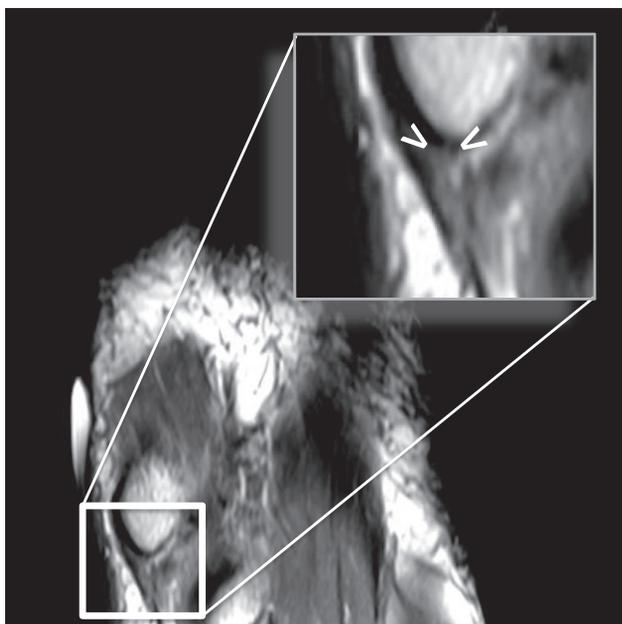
Axial T2-weighted and fat-saturated image of the right foot depicting the peroneal brevis at the insertion on the fifth metatarsal. Insert shows magnified view with abnormal signal within the peroneal brevis (arrowheads).
